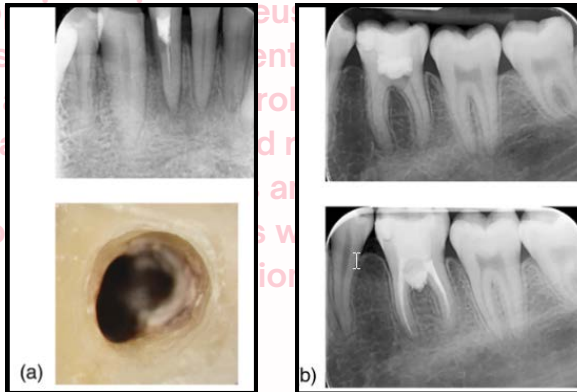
a) Lateral perforation of mandibular anterior (clinical and radiographic view)
